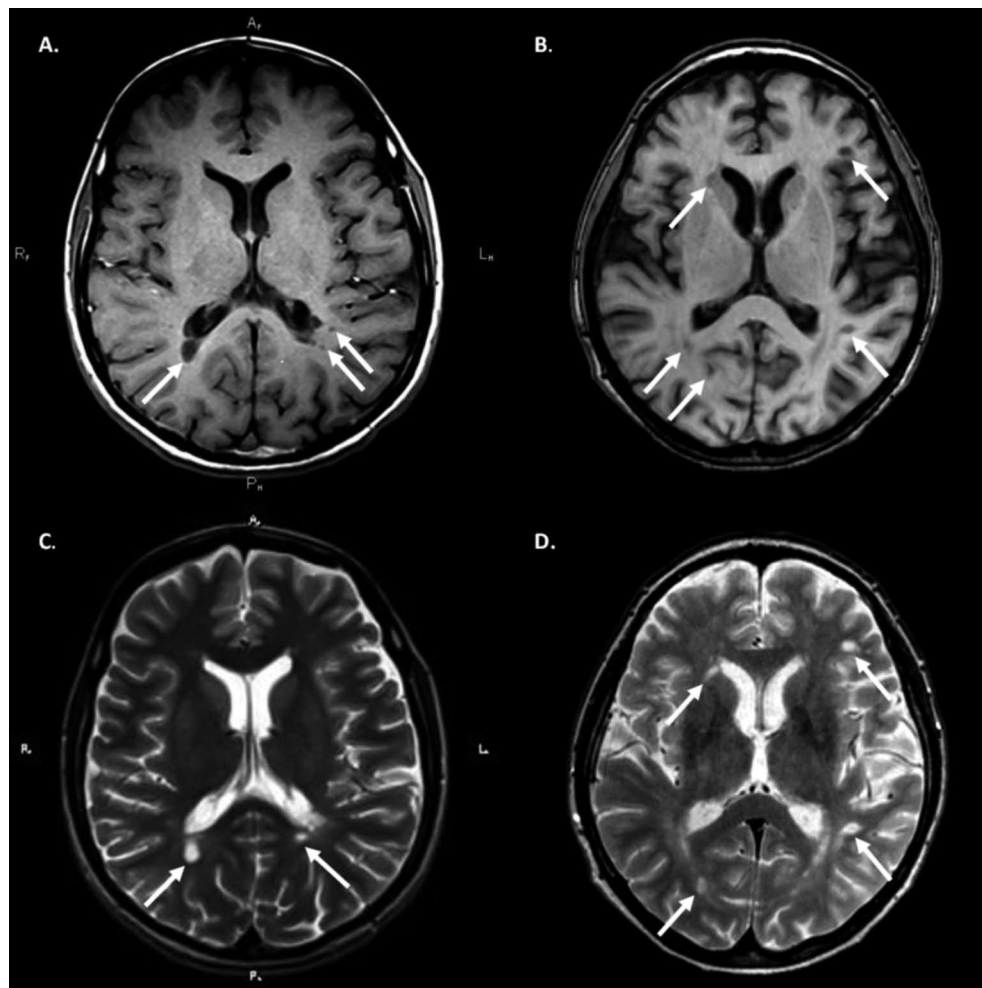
Axial T1- weighted (A, B) and T2- weighted (C, D) MR images in two multiple sclerosis female patients, confirmed as C341T mutation carrier (A and C) and C341T mutation non-carrier (B and D) matched for age, gender and disease duration. T1 and T2 lesions are indicated by white arrows.
